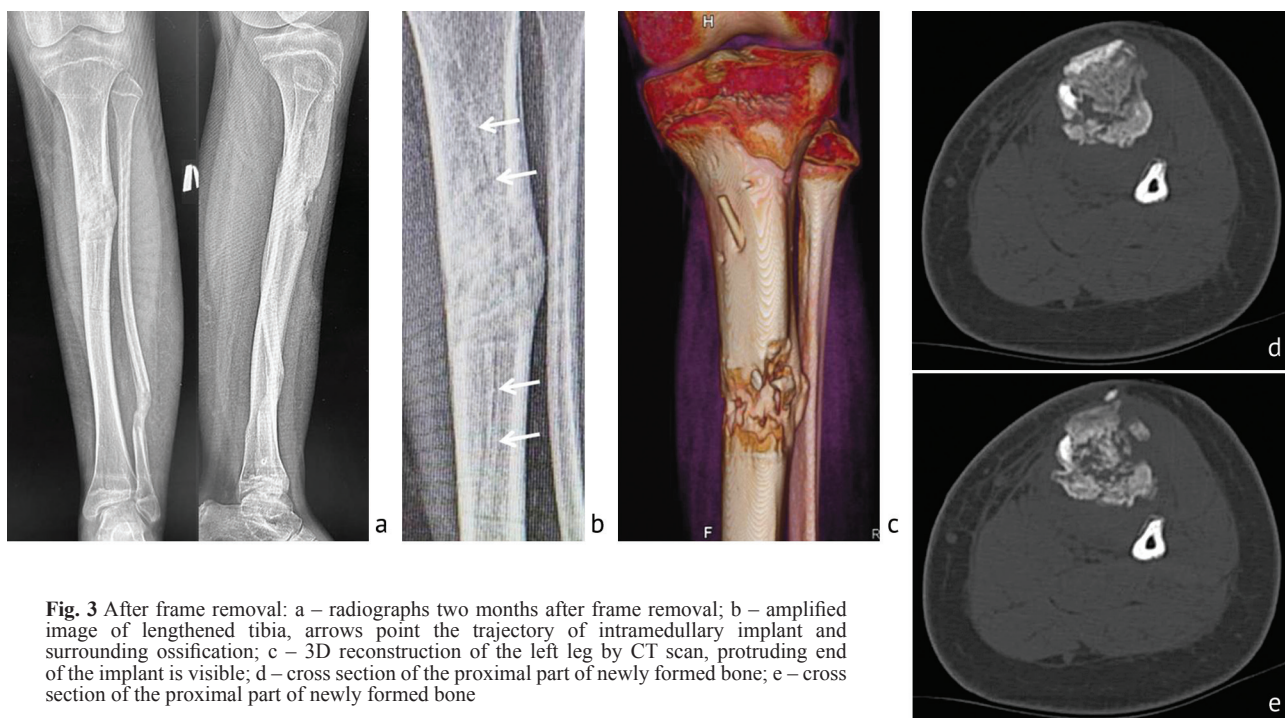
After frame removal: a – radiographs two months after frame removal; b – amplified image of lengthened tibia, arrows point the trajectory of intramedullary implant and surrounding ossification; c – 3D reconstruction of the left leg by CT scan, protruding end of the implant is visible; d – cross section of the proximal part of newly formed bone; e – cross section of the proximal part of newly formed bone
